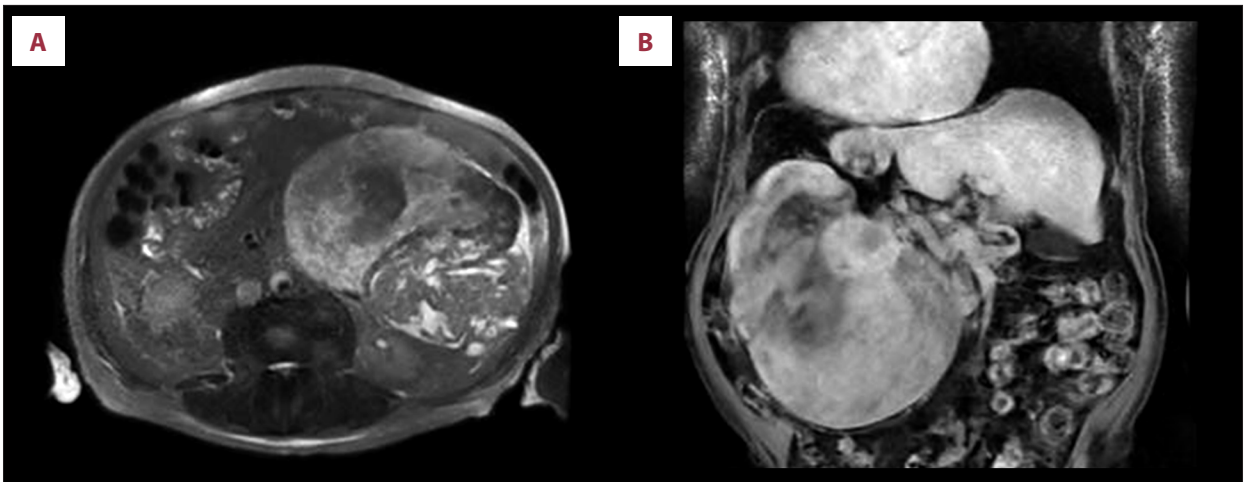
An axial T2 MRI demonstrating left-sided giant abdominal soft-tissue tumor (A). A coronal gradient echo MRI images demonstrating large left-sided abdominal soft-tissue tumor (B).
